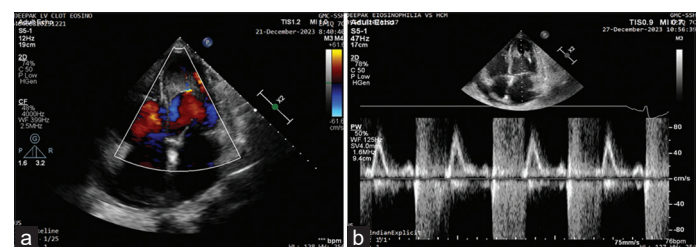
(a) Color Doppler showing flow through the obliterated apex, (b) Pulse waveforms across the mitral valve
